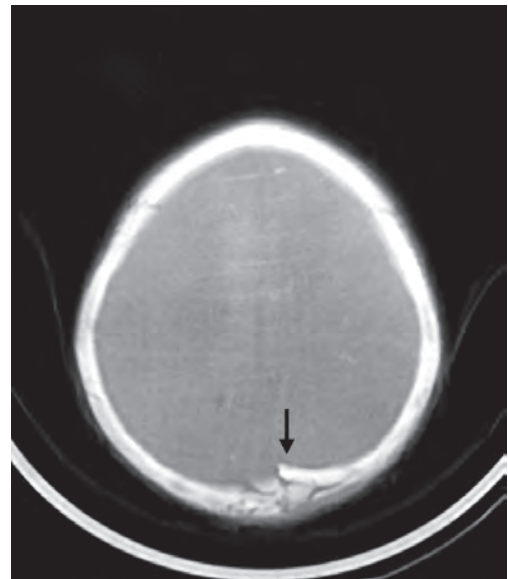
Depressed fracture CT
